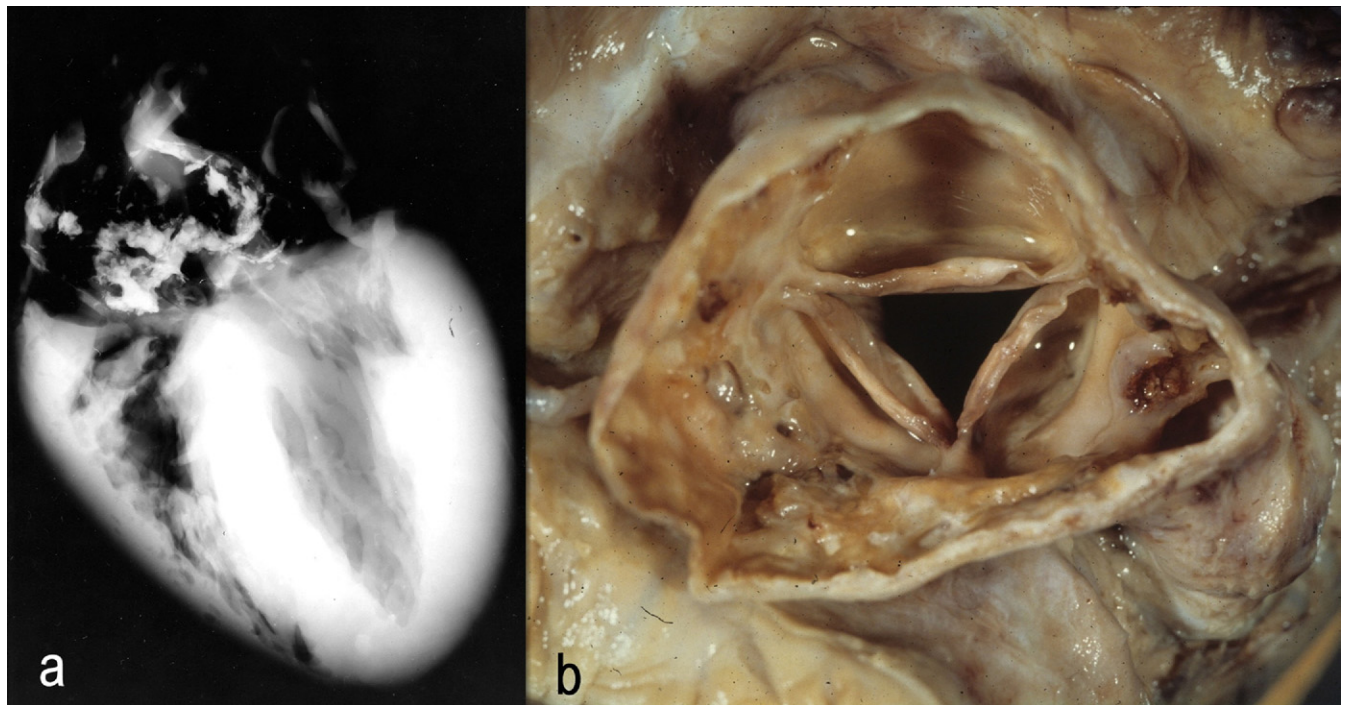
Radiograph of heart and proximal aorta (a) at necropsy and of aortic valve and proximal aorta from above (b) in 68-year-old African-American woman who had clinical evidence of aortic regurgitation and died from heart failure. Radiograph shows heavy calcific deposits in proximal aorta (a). Aortic valve orifice was triangular owing to dilation of ascending aorta. Tubular portion of aorta is diffusely involved by syphilitic process. Venereal Disease Research Laboratory serologic test result for syphilis was nonreactive.
